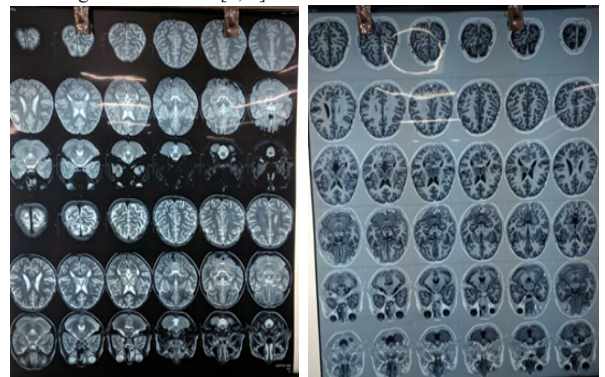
MRI brain showing Symmetric white matter hyperintensity is noted in bilateral lentiform nuclei ,caudate nuclei, thalami , PAG matter , pons with relative hypointensity involving the central tegmental tracts giving it a miniature panda sign . Area of hyperintensity noted in left frontal subcortical white matter. Mild prominence of ventricles , cisterns and sulcal spaces s/o cerebral atrophy.
